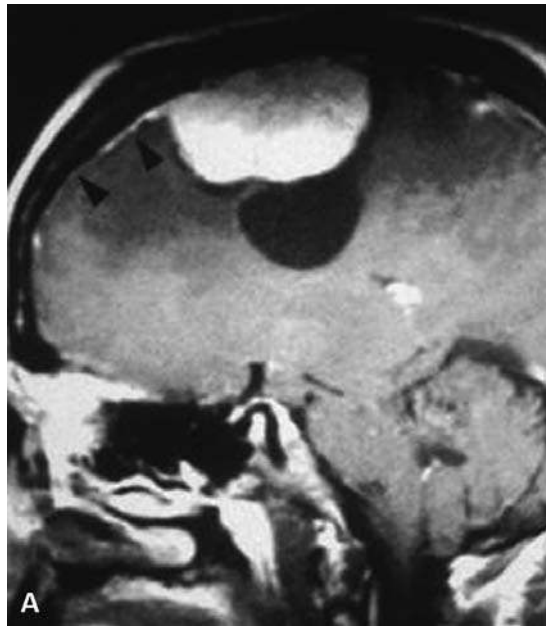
MRI appearances of conventional meningioma. (A) Convexity meningioma. (B) Intraventricular meningioma. (C) Base of the skull meningioma.
